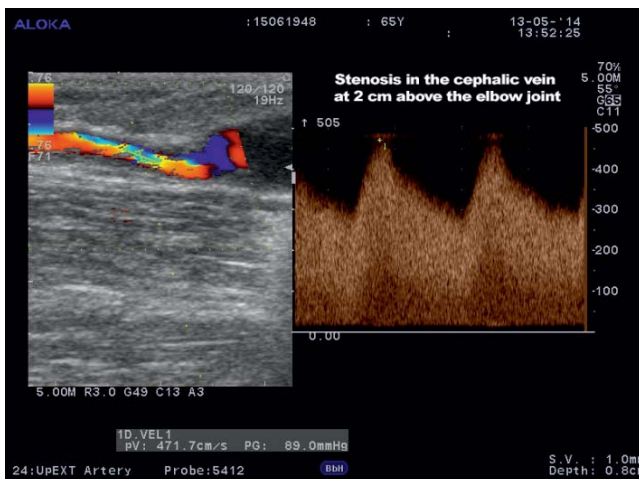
Color Doppler ultrasound of the cephalic vein. Stenosis at 2 cm above elbow joint.
